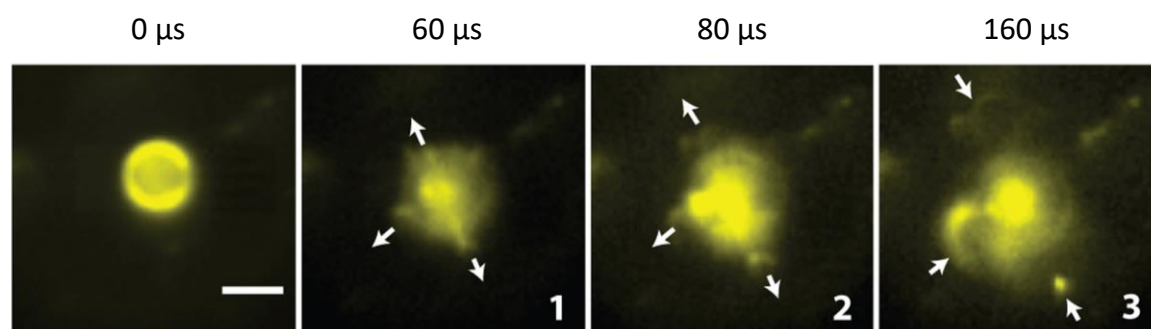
Images from [170] showing the shedding of fluorescent lipids during bubble oscillations with arrows indicating the motion toward/away from the microbubble during ultrasound excitation (255 kPa, 500 cycles), the scale bar is 5 μm .
